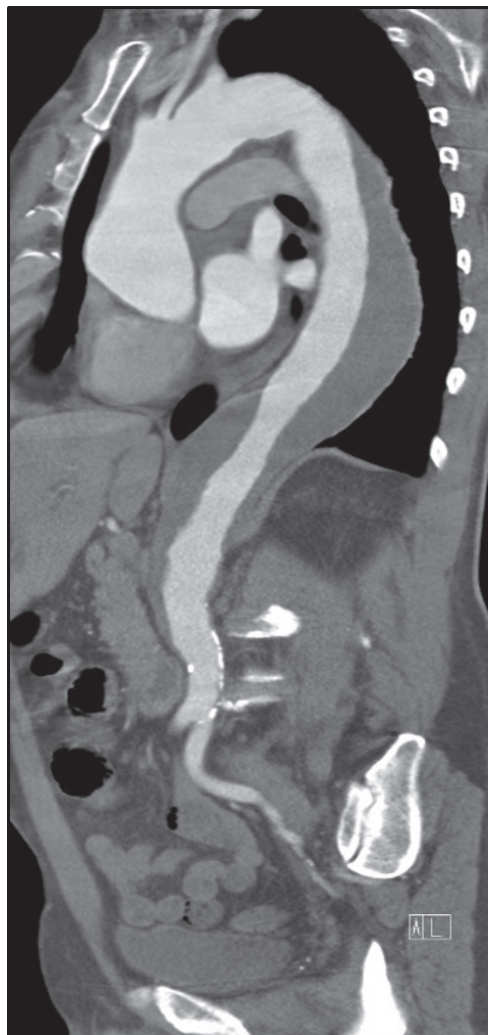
Preoperative CT scan showing the aneurysm involving the thoracic and abdominal aorta.
